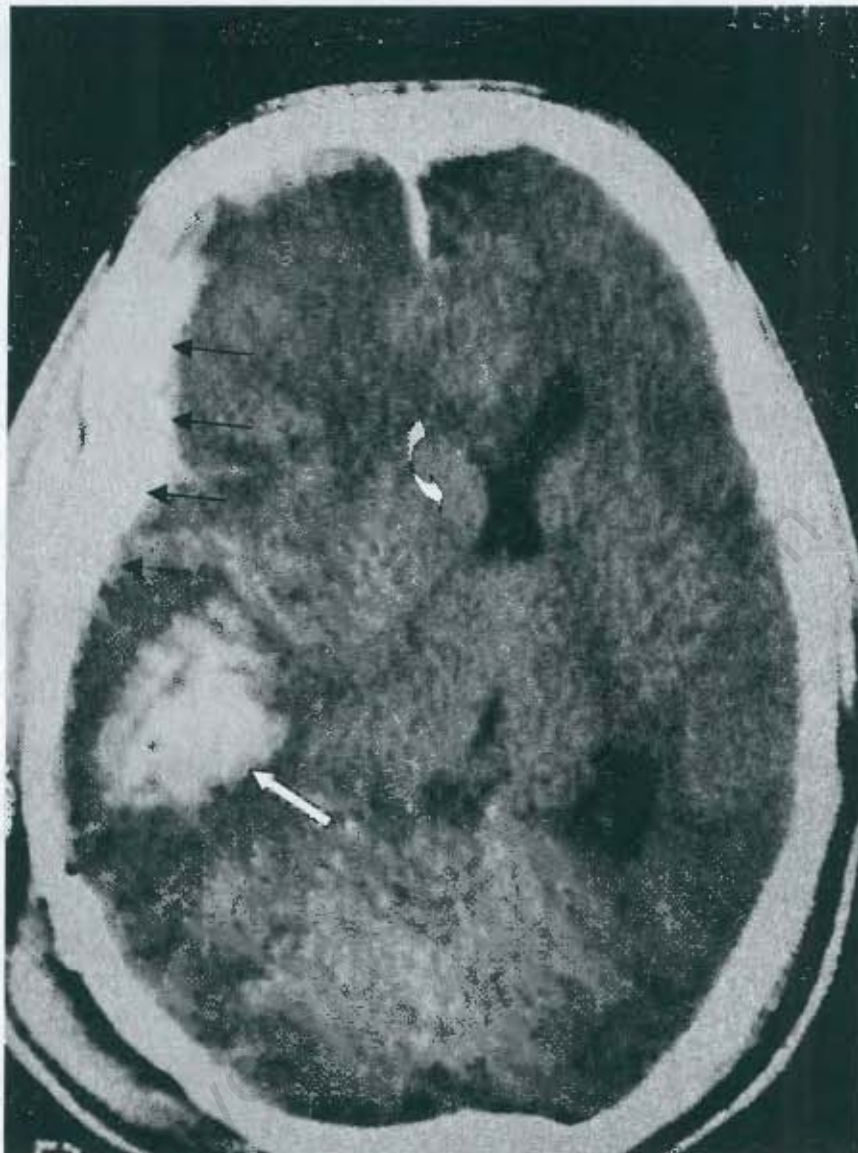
(B): Case 33. Axial CT brain demonstrating the acute right temporal lobe intraparenchymal haemorrhage (white arrow) and overlying right subdural haemorrhage (single arrows). Note also the mass effect with midline shift to the left (curved arrow).
